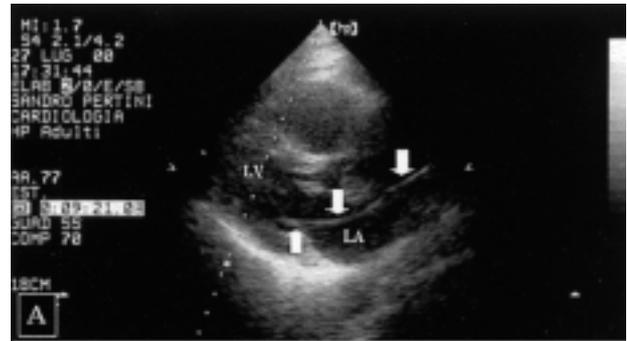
A: transesophageal echocardiogram (long-axis view) showing the position of the distal portion of the lead (arrows) in the lateral wall of the ventricle, crossing the left atrium (LA) and the mitral valve. B: transesophageal echocardiogram showing the position of the lead (arrows) through the atrial septal defect (C). LV = left ventricle; RA = right atrium.
